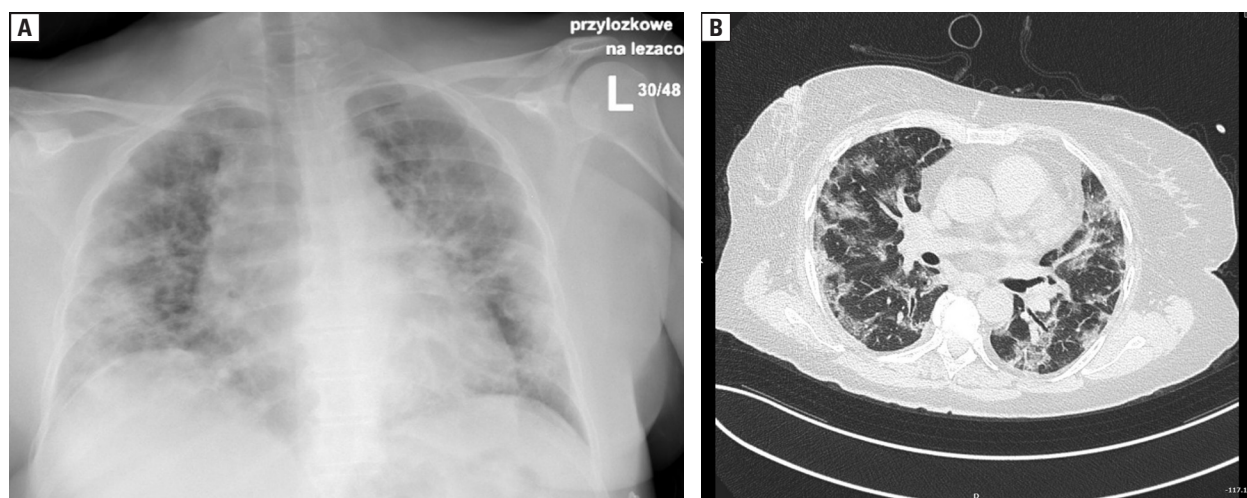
Picture of lung parenchyma involvement on the 4th day of treatment of 56-year-old woman infected with SARS-CoV-2. In chest anterior-posterior radiograph (A) and high resolution computer tomography (B) areas of ground glass opacities, mainly with sub-pleural predominance. Respiratory insufficiency. Treatment with Venturi mask — FiO_2 0.4 to be able to reach SpO_2 94%
